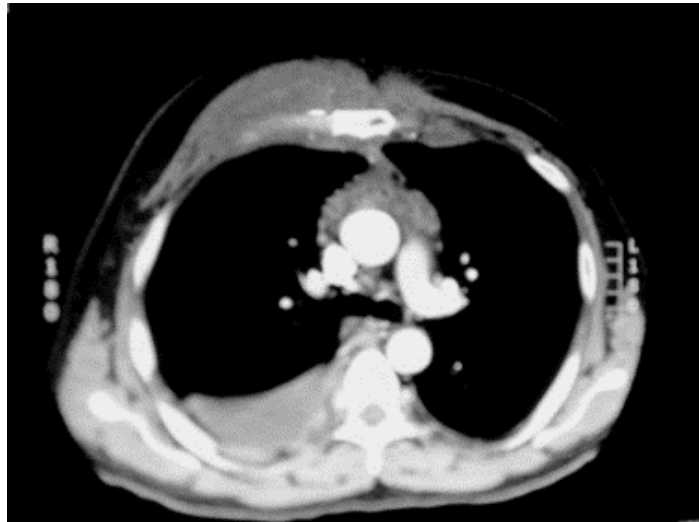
Thoracic computed tomography shows mediastinal lymph nodes, tumor masses in the anterior chest wall, and conglomerated lymph nodes in jugular chains
